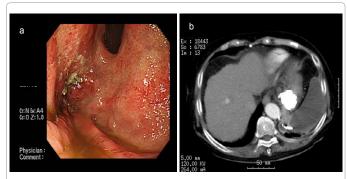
a: Endoscopy was performed 7 days later from EIS showed that the varices had markedly decreased. b: CT showed that blood flow were blocked completely.
